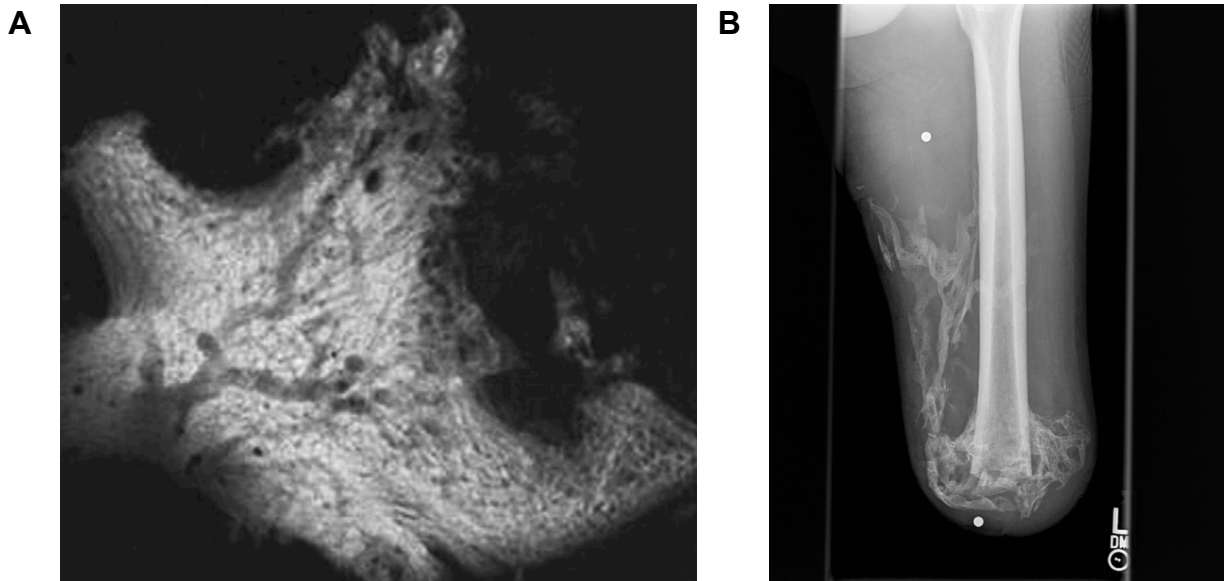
Radiographic imaging of human HO. A) Contact microradiograph demonstrating an extensive vascular network. Reproduced with permission from Isaacson *et al.*⁷⁸ B) Macroscopic clinical plain radiograph of a left femur with extensive terminal and medial HO. Reproduced with permission from Potter *et al.*³⁴
